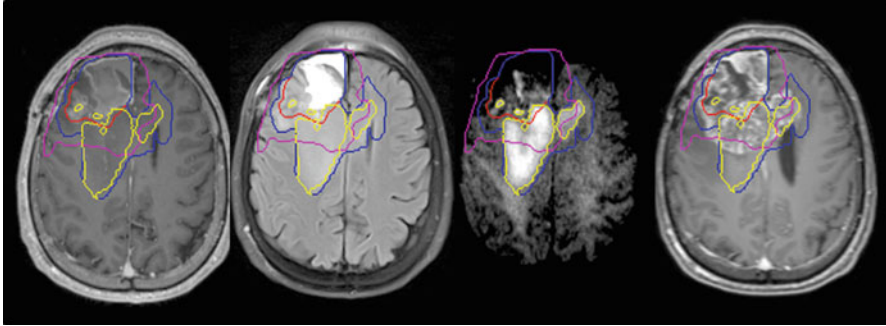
Post-Gd T1-weighted image pre-RT (*left*), T2 FLAIR image pre-RT (*second left*), diffusion weighted image with b-value of 3000 s/mm² pre-RT (*second right*), and post-Gd T1 weighted image 4-month post-RT at progression (*right*) of a patient with glioblastoma. Contours: Gross tumor volume based upon contrast enhancement (*red*), FLAIR abnormality volume (*yellow*), hypercellularity volume (*yellow*) and 95% of the prescribed dose volume (*pink*). *Gd* gadolinium, *RT* radiotherapy
